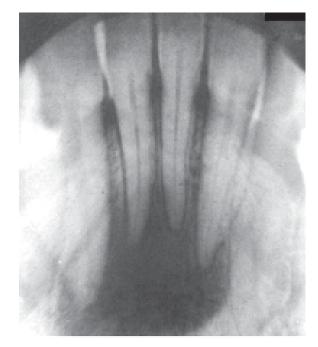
Mandibular Occlusal. X-ray showing well-defined periapical radiolucency in relation to the mandibular anterior teeth which is suggestive of periapical granuloma
